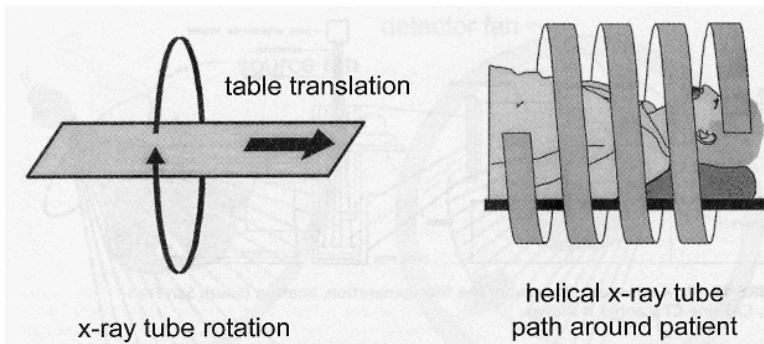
With helical computed tomographic scanners, the x-ray tube rotates around the patient while the patient and the table are translated through the gantry. The net effect of these two motions results in the x-ray tube traveling in a helical path around the patient.
